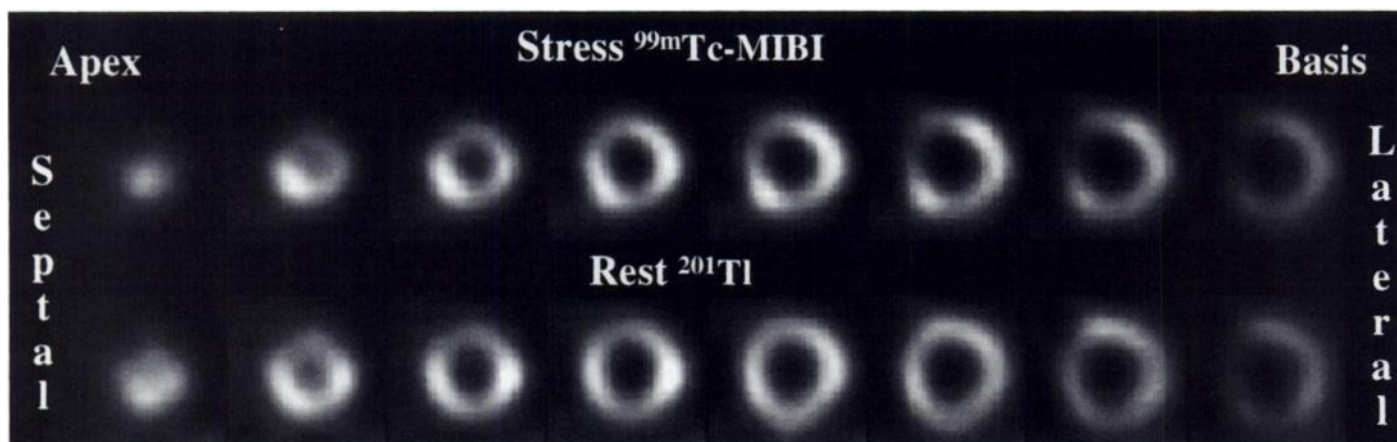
Short-axis SPECT images of patient with sequential coronary stents in proximal portion of LAD. At time of stent implantation, significant stenosis developed at origin of septal branch artery in this patient. Technetium-99m-MIBI stress images show small area with hypoperfusion in basal, antero-septal region. Thallium-201 rest images demonstrate normal tracer distribution. Coronary angiography demonstrated no significant restenosis in region of implanted stents. Reversible perfusion abnormality on stress scintigraphy corresponds to stenosis of side branch artery.
